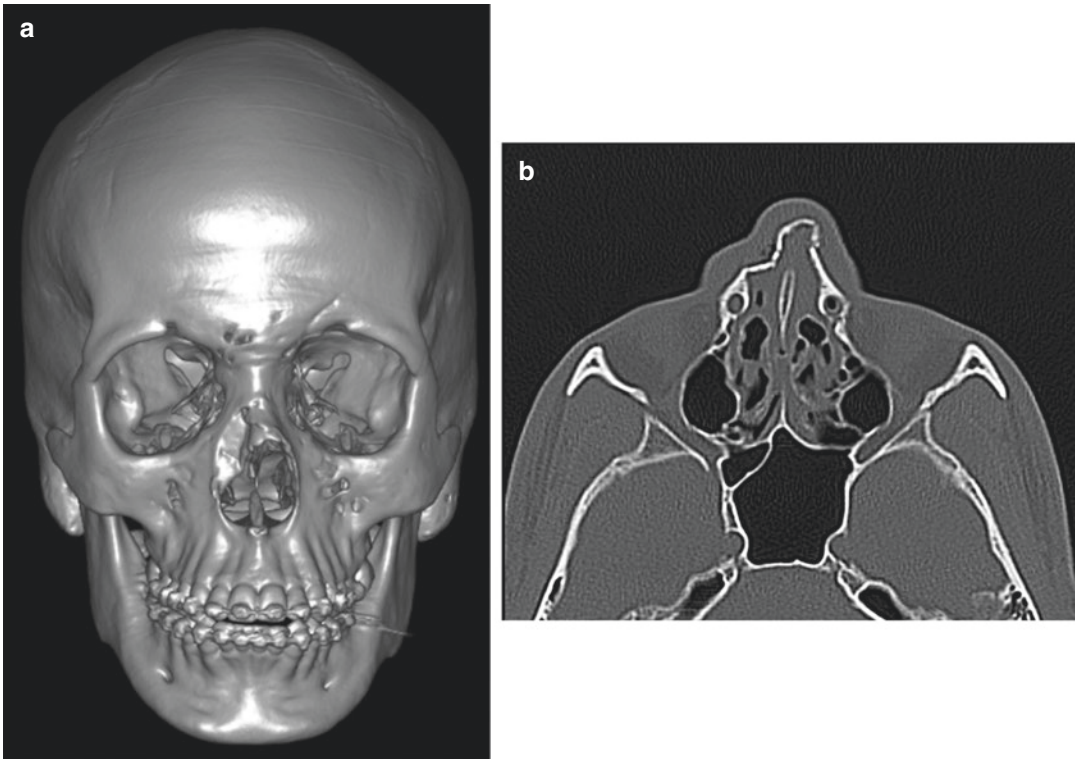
CT images showing a comminuted nasal fracture in a karate fighter in (a) 3D reconstruction and (b) axial views. With permission from Daniel Miranda Ferreira
